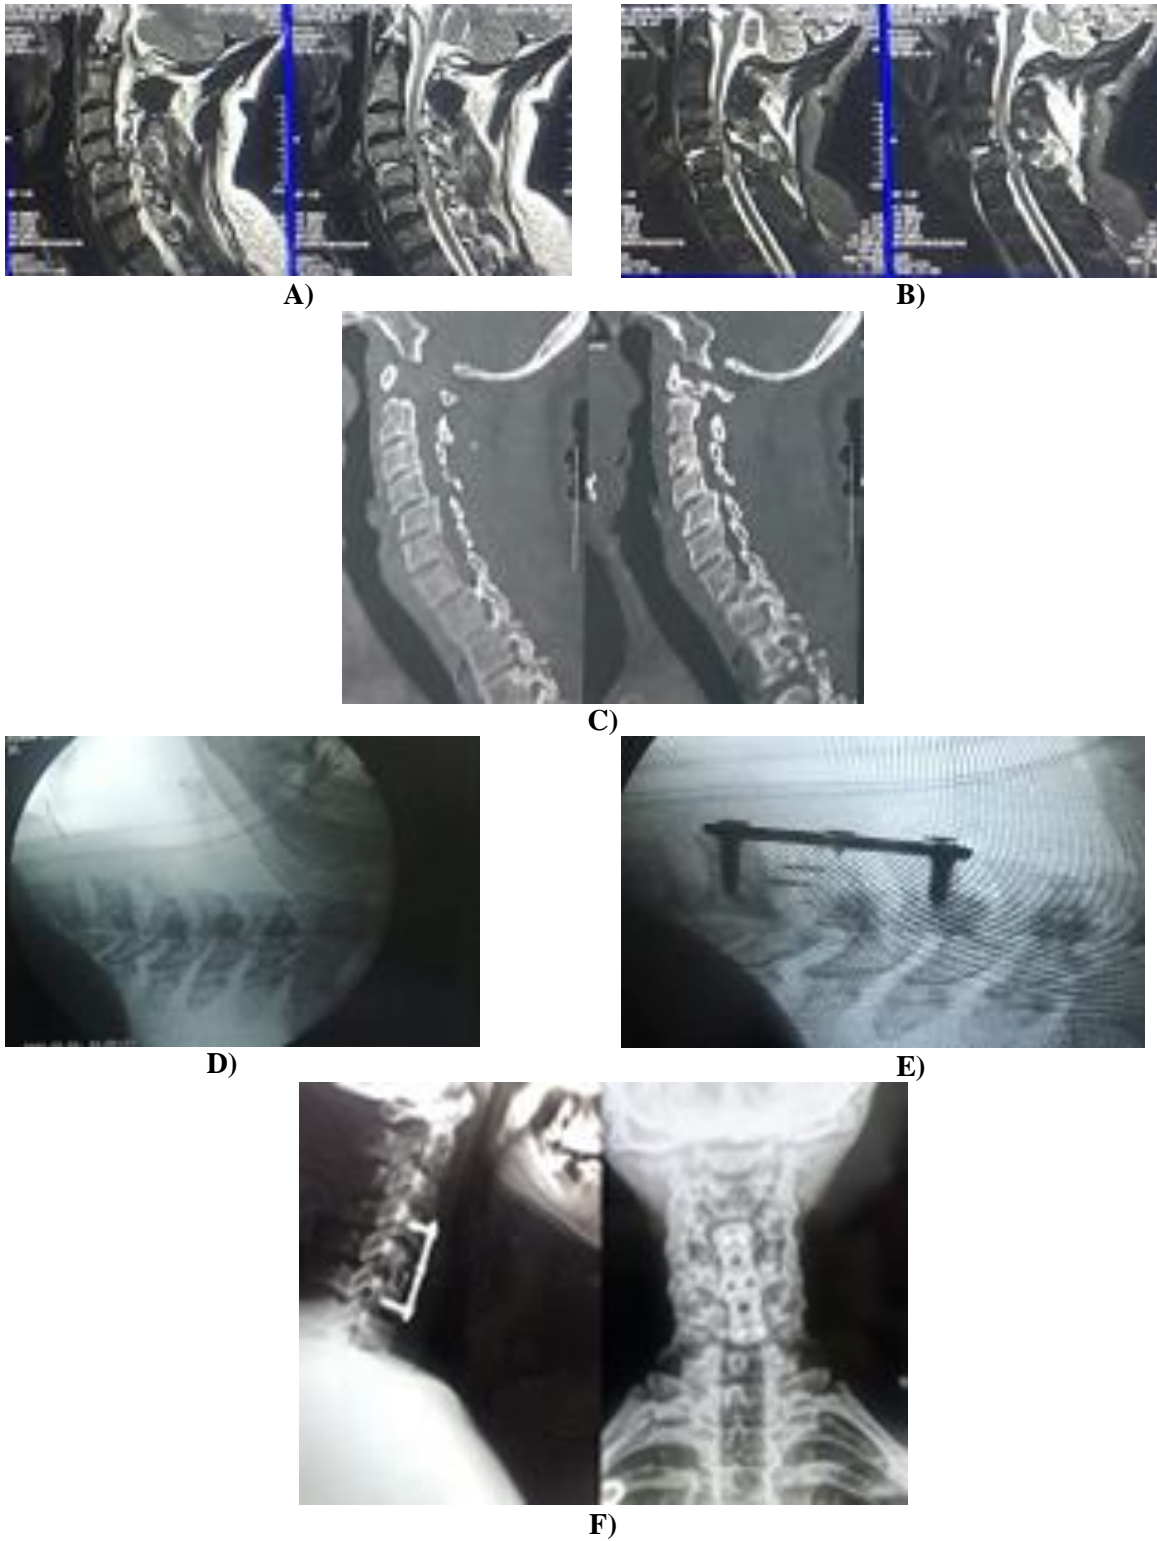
(A and B) MRI and CT (C) show displaced C4-5 with disrupted disc, (D) Intraoperative images under C arm reduction achieved and detection of the level with mark (E) After placement of the cage and the plate, (F) Follow up X ray showing reduction with fixation and good alignment of the cervical spine.
